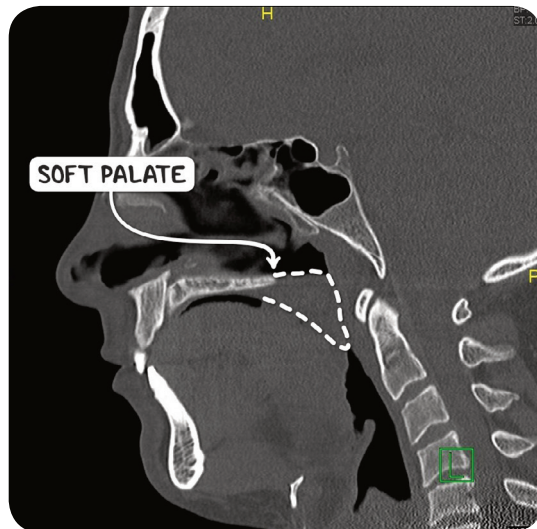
A CT scan of the head and neck in the sagittal plane. The soft palate is elongated, thickened and abutts the posterior pharynx, leading to obstructive sleep apnea.
